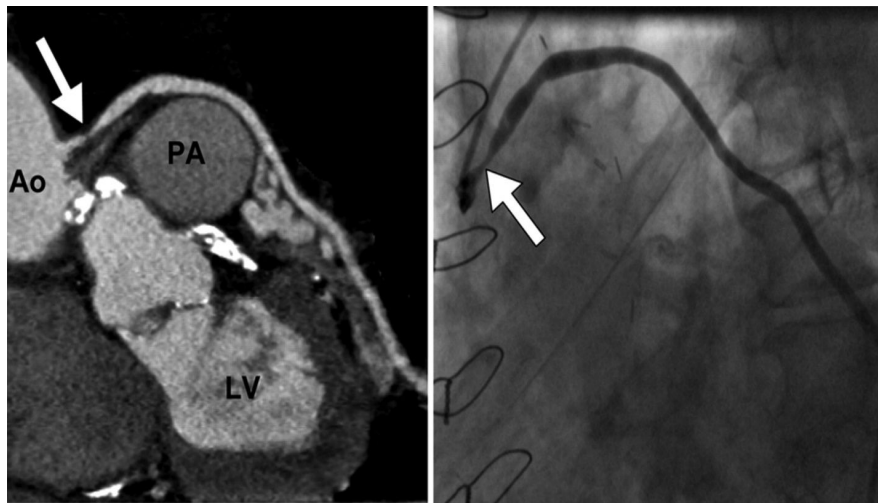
Coronary artery bypass graft imaging with multi-detector row computed tomography.
